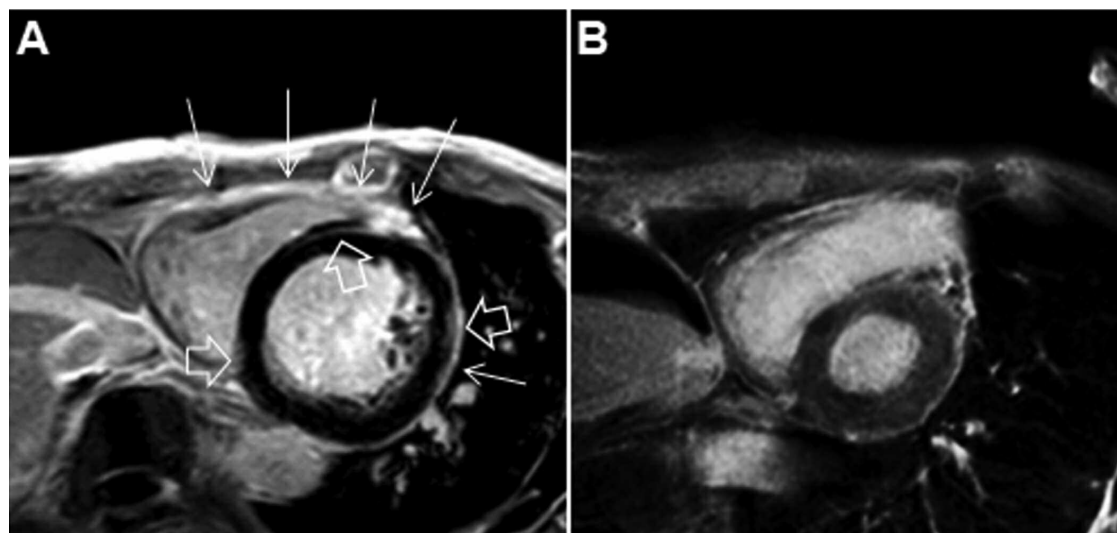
Serial cMRI images of case 1. A. Pre-RTX treatment cMRI late gadolinium enhancement (LGE) image shows pericarditis with enhanced thick pericardium (white arrows) and acute myocardial edema with linear LGE (white hollow arrows). B. Post-RTX treatment image discloses completely resolved myocardial edema and lessened pericardial enhancement. cMRI: cardiac magnetic resonance imaging; RTX: rituximab.
